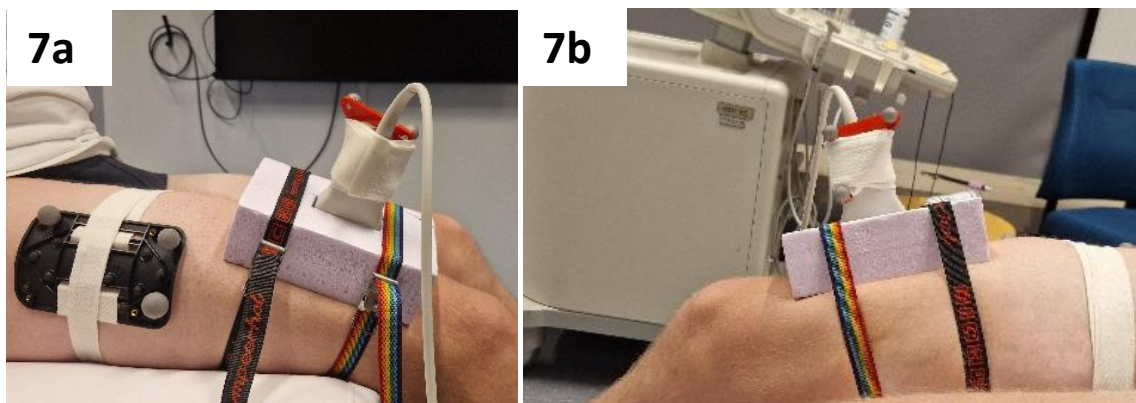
Ultrasound probe with probe-stabiliser fixed to the thigh with strap-bands. Clusters of reflective markers are fixed to the thigh (7a) and probe (7a and 7b). Used during measurement of angle-specific relaxed fascicle length and active fascicle length.
